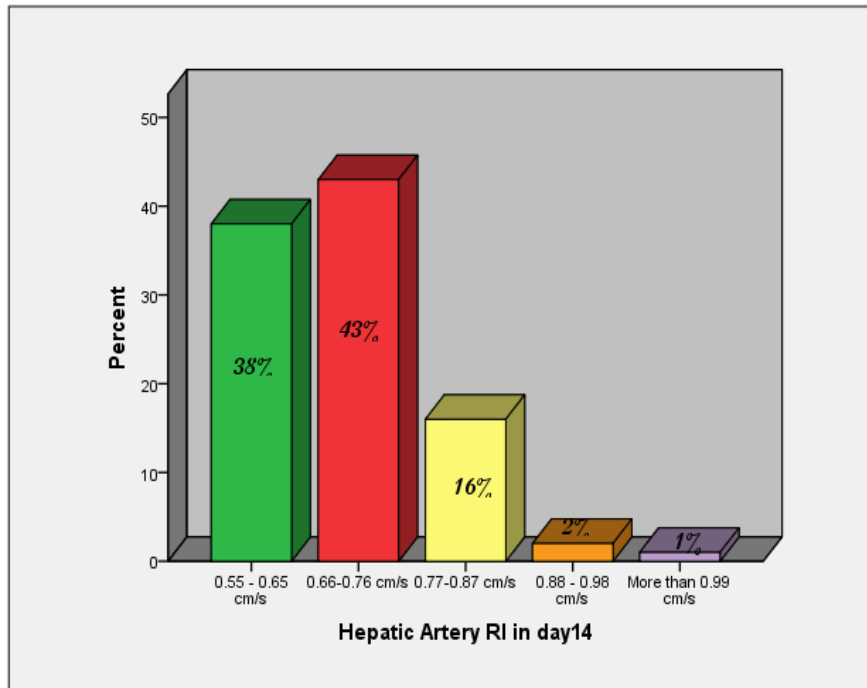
Frequency distribution of Doppler RI for hepatic artery in day 14
